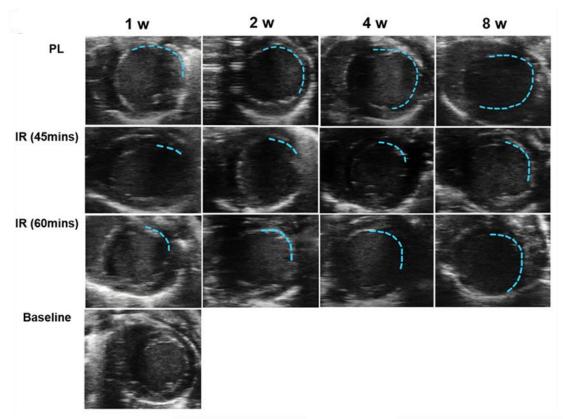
Representative ultrasound images in a short-axis view of the infarcted LV obtained at different time points post-LAD ligation in baseline, PL or IR models (n = 6 per group). The regions outlined in dashed blue lines are indicative of ischemic damage. PL, permanent ligation; IR, ischemia—reperfusion.
